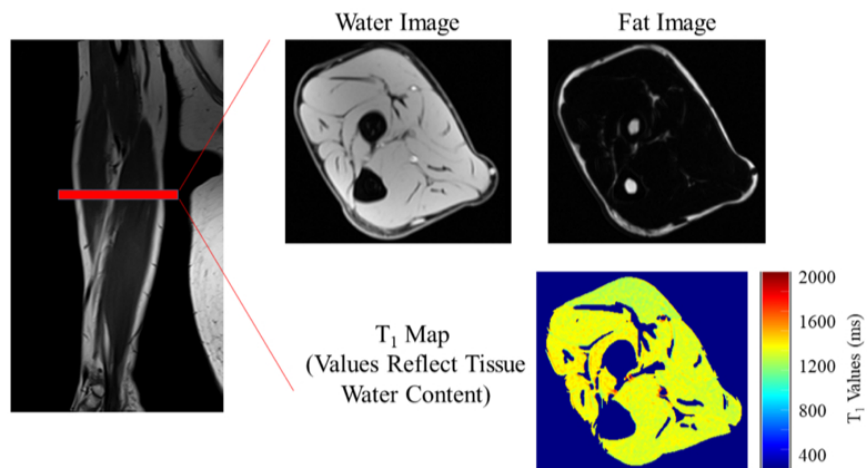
MRI one sample slice
